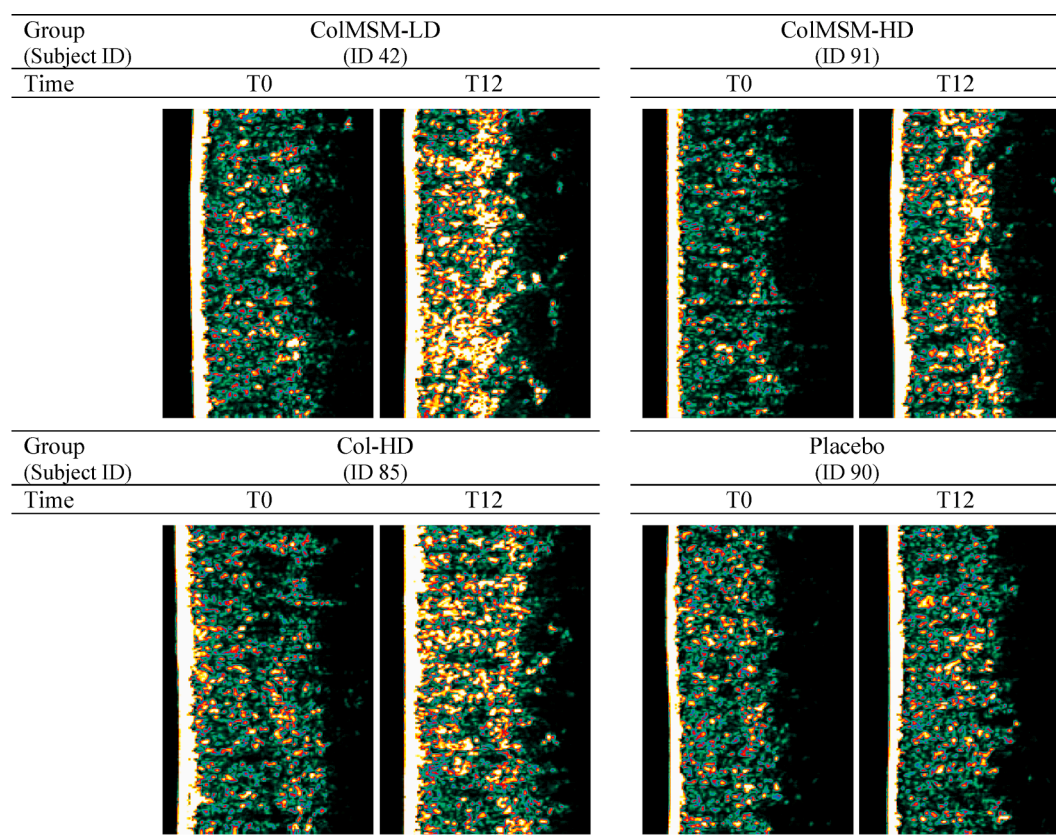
Examples of the effects of intervention on the dermis on subjects from different groups: ultrasound images of the dermis at baseline (T0) and 12-week follow-up (T12). The white line to the left represents the epidermis with a water film, followed by the dermis to the right, characterized by varying intensities, and the subcutis by low-intensity areas due to a homogenous composition. Echogenicity colour scale: white > yellow > red > green > black. An increase in dermis echogenicity is visible in the images of the subjects in the ColMSM-LD, ColMSM-HD and Col-HD groups, indicating an improvement in dermal density during the study, while no important changes can be observed in the images of the subject from the placebo group.
